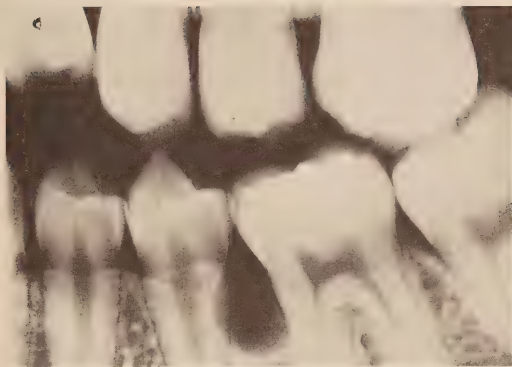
Radiograph of an odontogenic keratocyst (lateral periodontal cyst type) between the mandibular second bicuspid and the first molar. The cyst appears to be unilocular.
